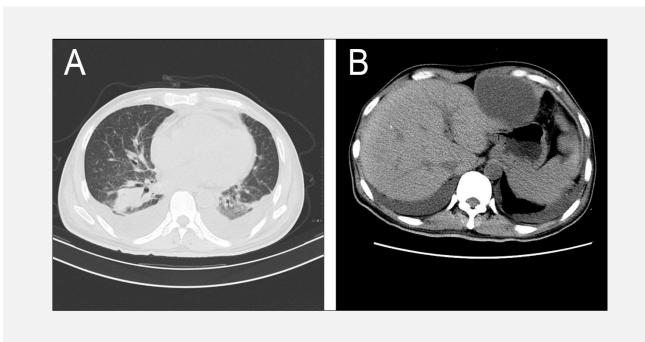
A. CT scan of the thorax shown with diffuse small pulmonary nodules, pulmonary effusion. B. CT scan of abdomen with enlargement of spleen with multiple low-density nodules.
